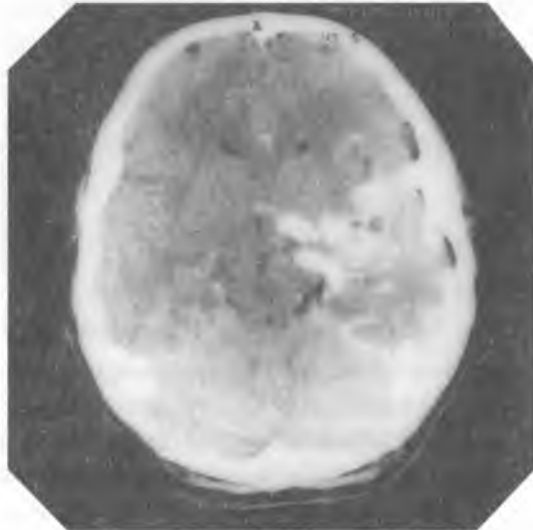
CT – after contrast administration – intensely hypodense band-shaped structures
